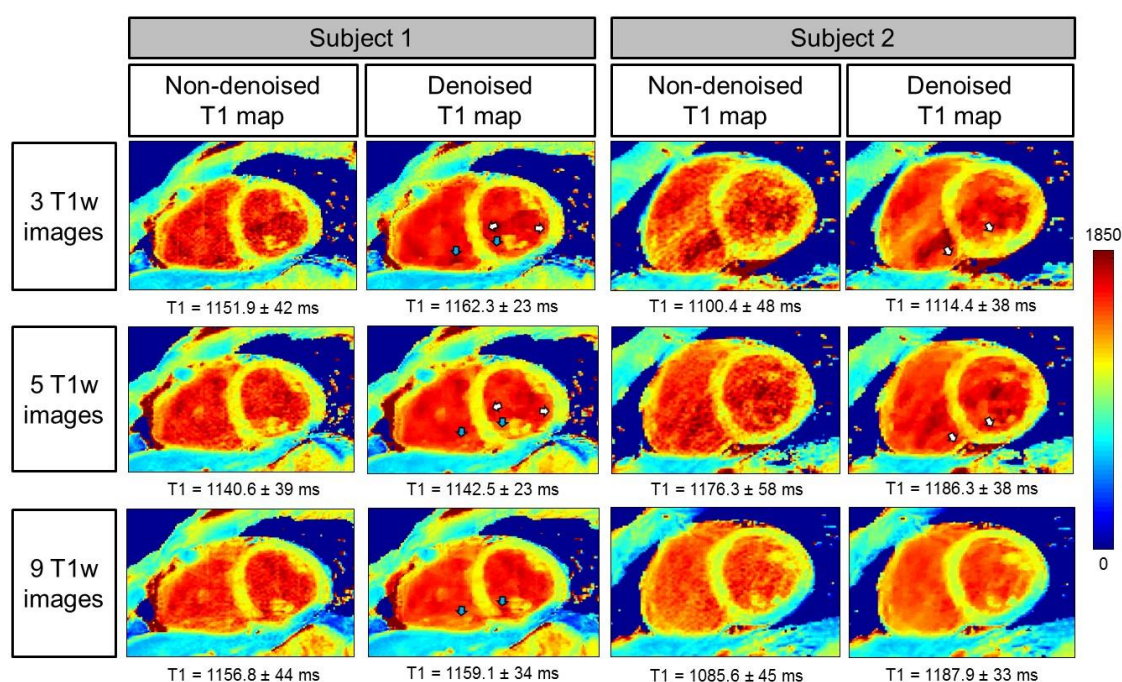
3D SASHA T1 maps of two representative subjects acquired prospectively with three, five and nine T1-weighted images along the saturation recovery curve. The accuracy and precision measured in the myocardial septum are indicated for each T1 map. T1 maps were reconstructed before and after 3D denoising. There was an improvement in the image quality in terms of myocardial and pupillary muscles delineation after 3D denoising (white arrows). Motion artefact (blue arrows) can be introduced if more images are acquired due to the longer scan time.
